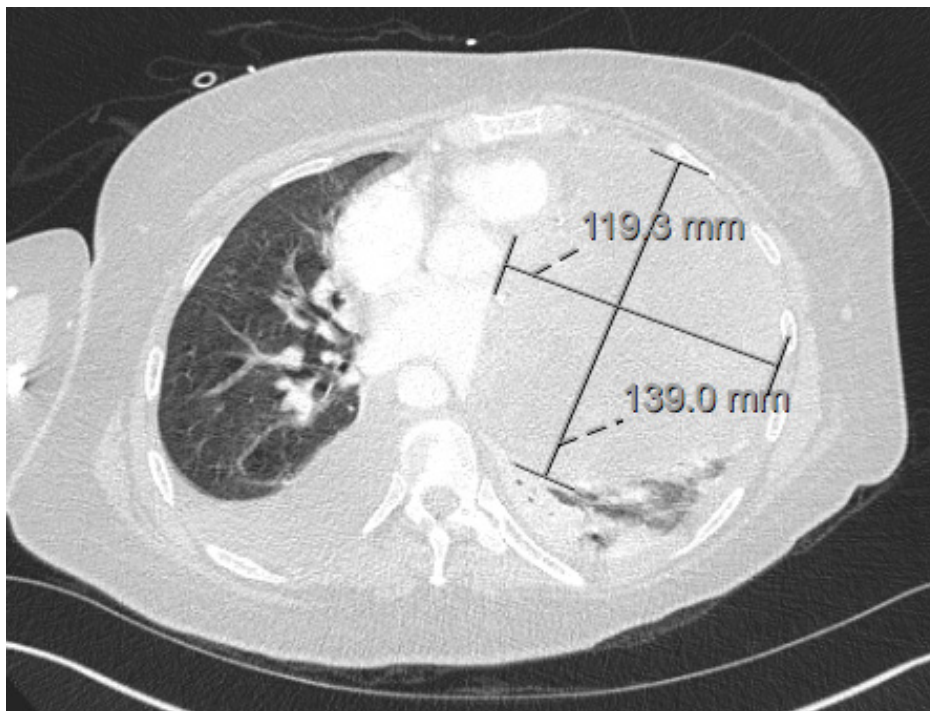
CT showing moderate left pleural effusion and a large pericardial effusion with mass effect on the main pulmonary artery, left ventricle, and left pulmonary veins.
